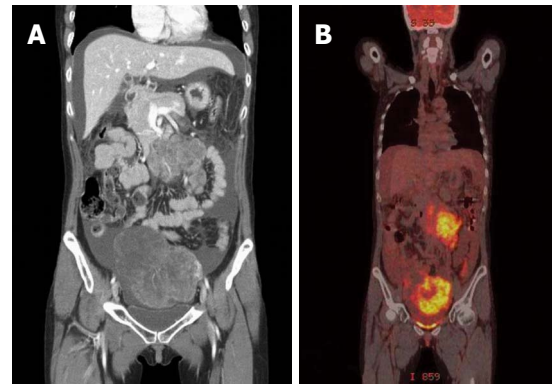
A huge heterogeneous enhancing ovarian mass and peritoneal metastatic lesions were observed. A: Computed tomography (CT) scan; B: Positron emission tomography-CT scan.
